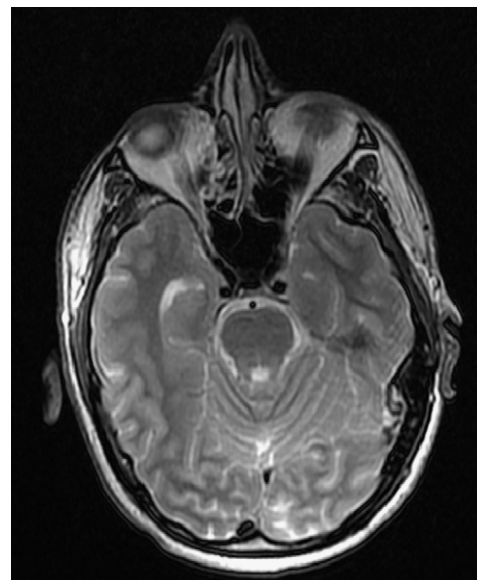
MRI scan at slice of cranial vault.
